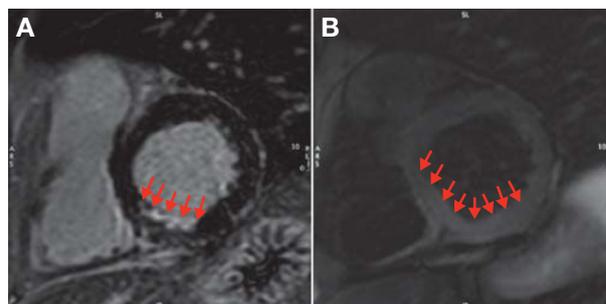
A) LGE image - subendocardial inferior myocardial infarction. B) T2-weighted image of “area at risk.”
